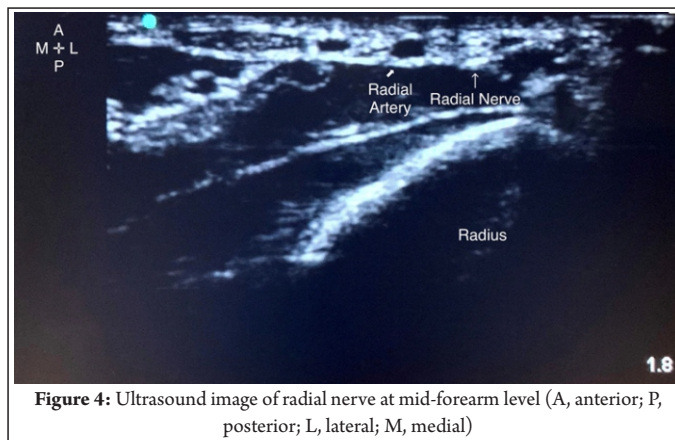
Ultrasound image of radial nerve at mid-forearm level (A, anterior; P, posterior; L, lateral; M, medial)
